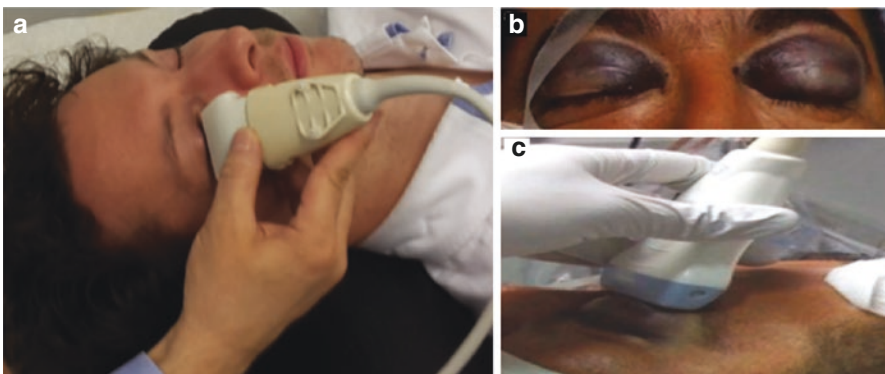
(a) Acoustic window ultrasound: Lower eyelid approach. (Modified from Schmidt et al. [20]); (b) Skull base fracture (“Raccoon Eyes”): where eyelid retraction is impeded or when pupillometry is unavailable; (c) Acoustic window ultrasound: Upper eyelid approach. (Courtesy: Sangsyan et al. [22])
